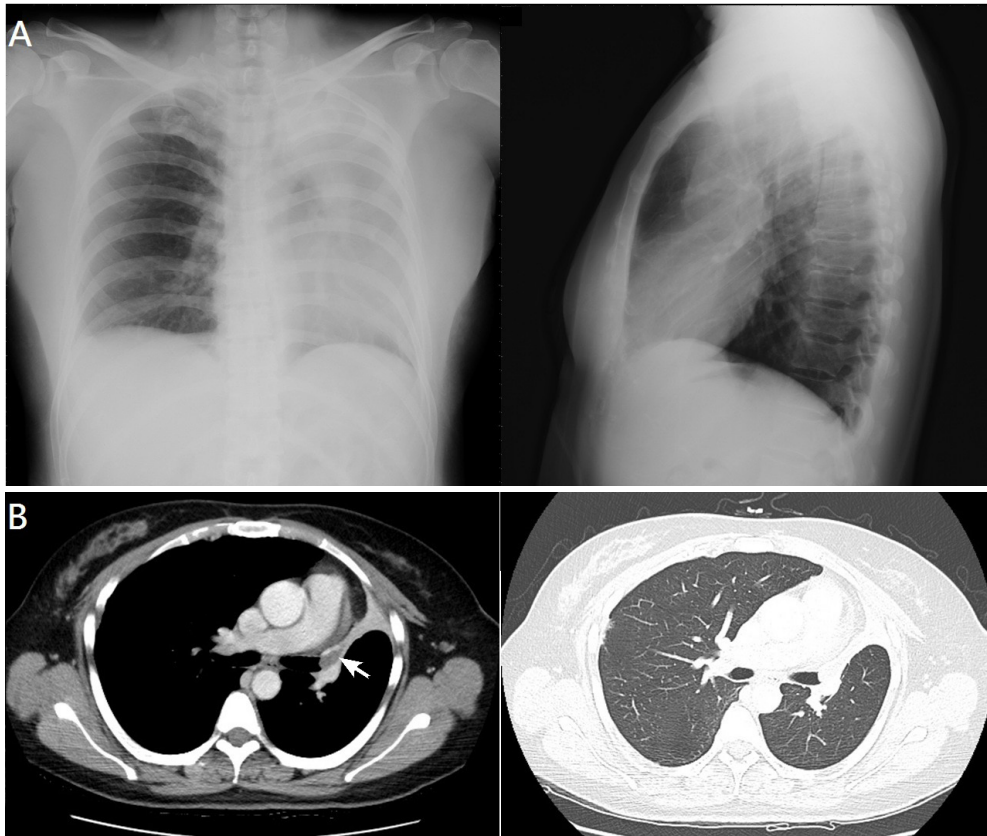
(A) Chest radiograph showed fracture of the right 5th, 6th, and 7th ribs and collapse of the left upper lobe. (B) Chest computed tomography revealed a soft tissue (arrow) obstructing the left upper lobe bronchus and atelectasis of the left upper lobe.
